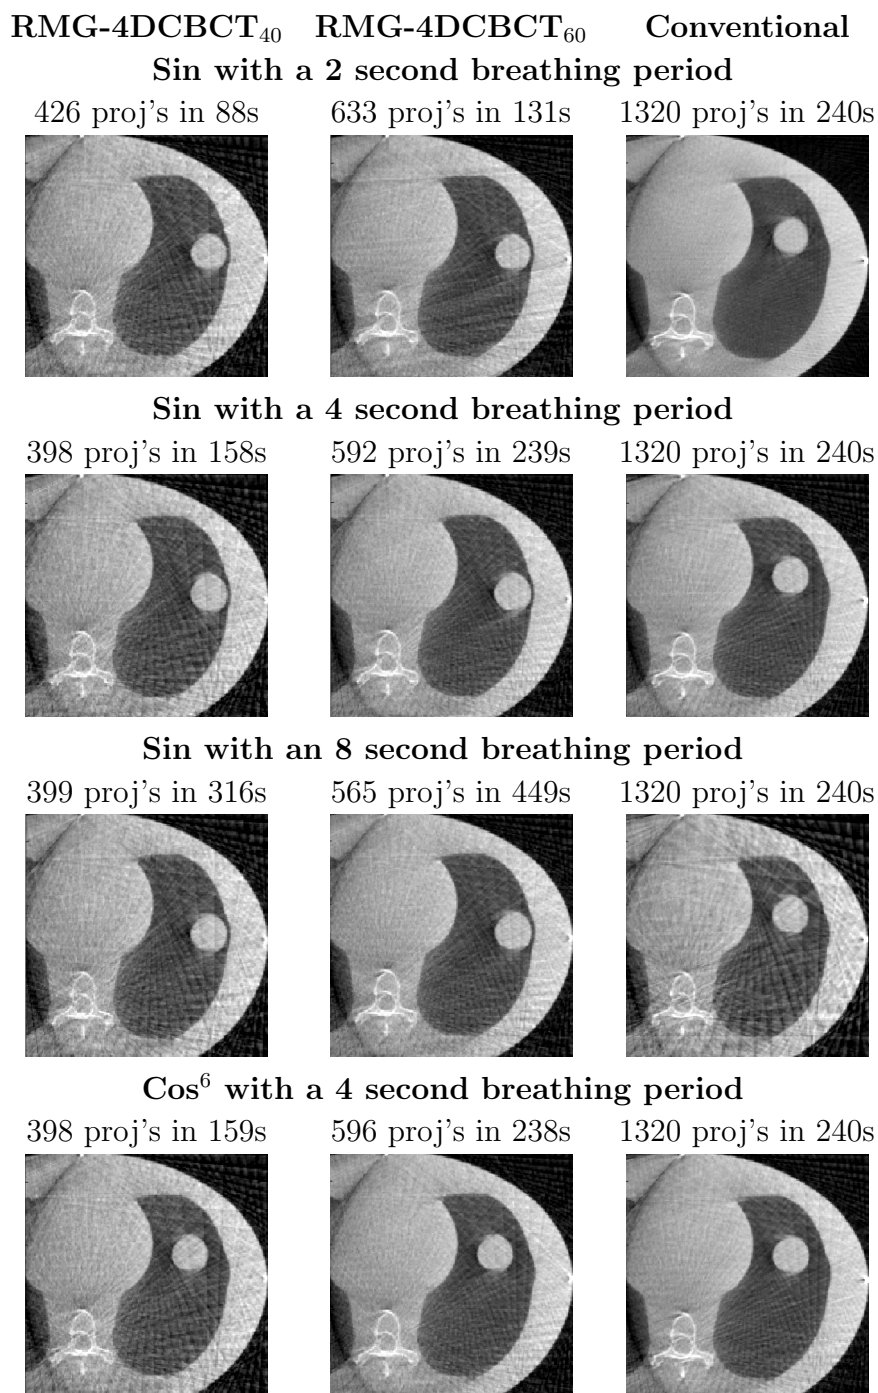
A transverse slice of the peak inhale phase bin with RMG-4DCBCT₄₀, RMG-4DCBCT₆₀ and conventional 4DCBCT for a variety of different sinusoidal breathing rates. Also listed are the total number of projections across all 10 phase bins and the image acquisition time.
